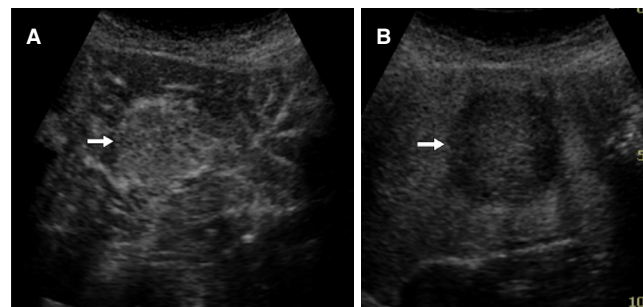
Hepatocellular carcinoma. A: contrast-enhanced ultrasonography shows homogenous strong enhancement (arrow) in the early arterial phase; B: a clear defect (arrow) with an irregular border is observed on a Kupffer phase image
